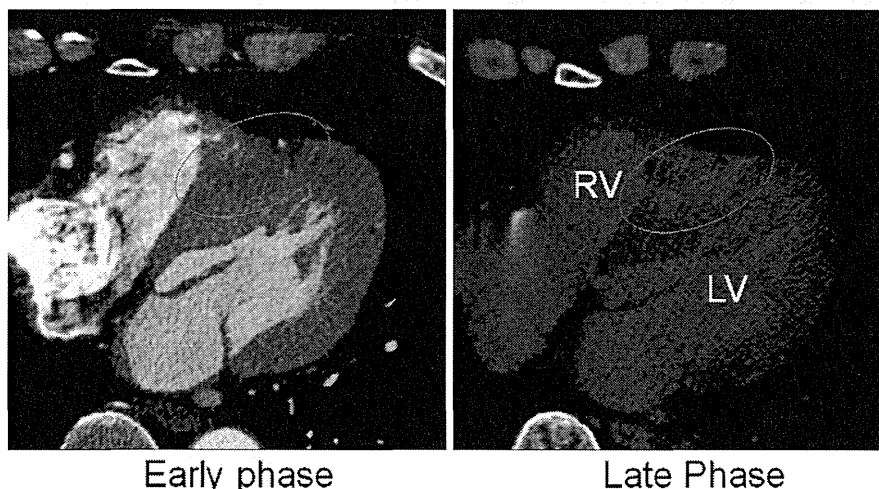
Axial source images of enhanced multislice computed tomography in a subject with hypertrophic cardiomyopathy (asymmetrical septal hypertrophy type) acquired at 30 s (early phase) and 6 min (late phase) after injection of contrast material. Fibrotic lesion was defined as contrast defect in the early phase and abnormal enhancement in the late phase. Fibrotic lesions (surrounded by red circles) can be observed in hypertrophic inter ventricular septum and apical antero-septum. RV and LV indicate right and left ventricles, respectively.
